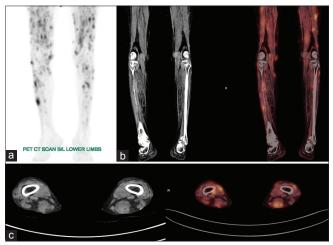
(a) 18FFDG PET CT scan in maximal intensity projection (MIP) view of bilateral lower limbs shows numerous sites of linear and patchy FDG uptake (maximal standardized uptake value – 5.3) in the skeletal muscles and cutaneous tissue in the bilateral lower limbs. (b and c) are coronal and axial CT and fused PET CT images demonstrating diffuse muscle atrophy with multiple metabolically active lesions in skeletal muscles and cutaneous tissue (white arrow)
